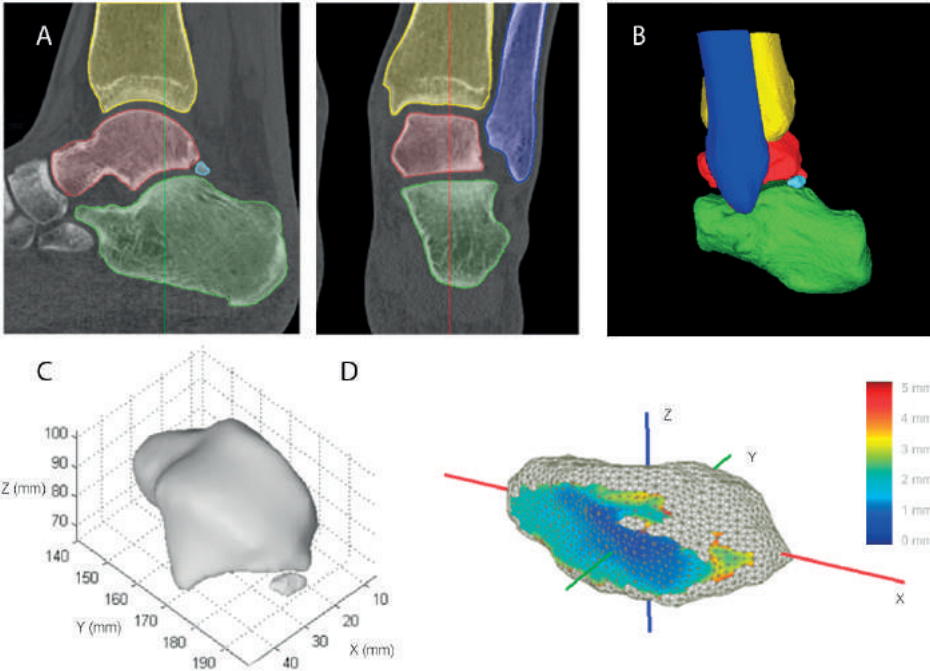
A. Segmentation of CT scan using Seg3D. B. Isosurface data points created using Seg3D. C. Triangulated surface models of talus and os trigonum as created in Matlab. D. Triangulated surface model of the os trigonum with the three geometric principal axes. The colour map represents the distance (mm) between os trigonum and talar bone as calculated in Matlab. A and B: yellow: tibia; red: talus; green: calcaneus; dark blue: fibula; light blue: os trigonum.
